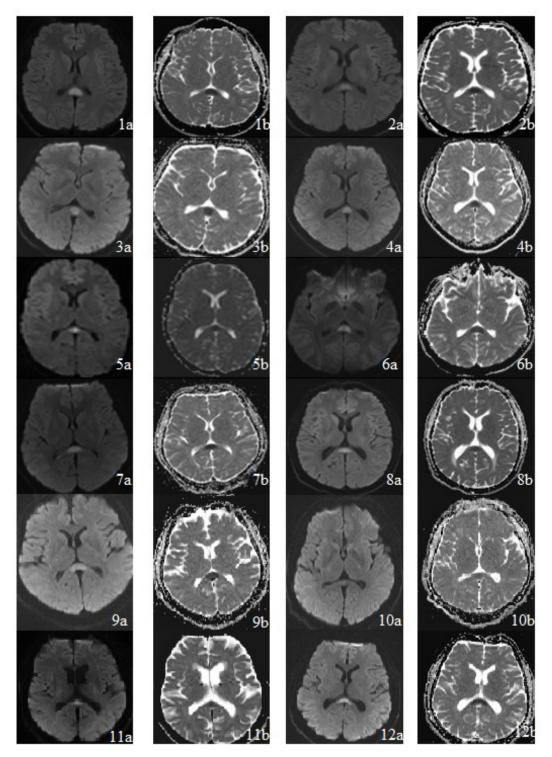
Brain diffusion-weighted magnetic resonance imaging and apparent diffusion coefficient (ADC) map in cases 1-12.
